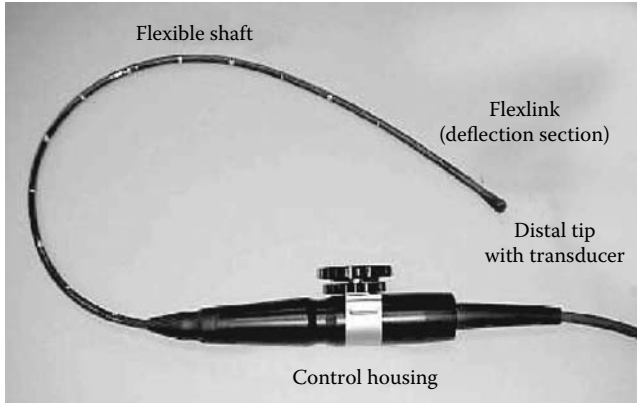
A photo of a transesophageal probe. (Courtesy of Oldelft B.V., Delft, the Netherlands.)
